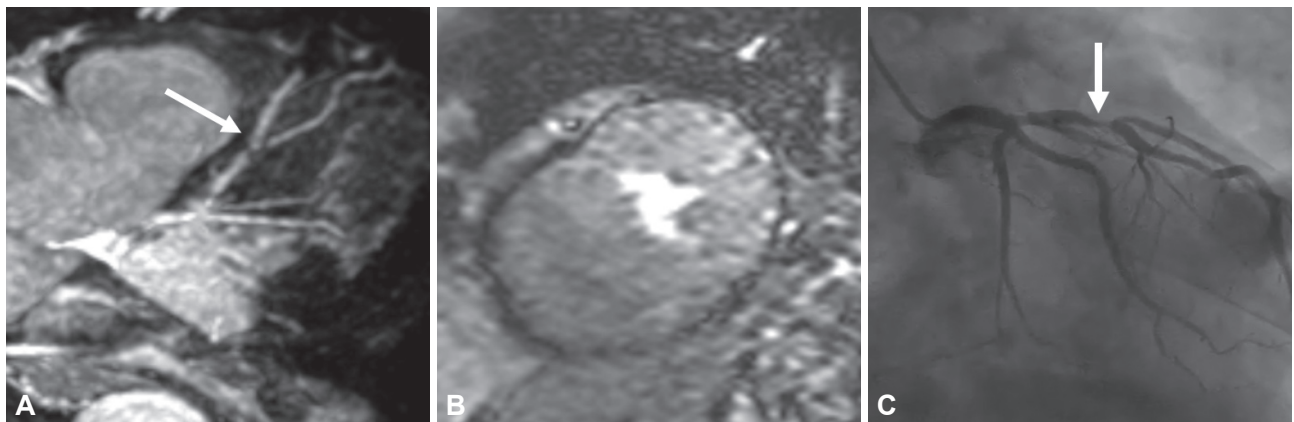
(A) Coronary MRA in a 67-year-old man with chest pain revealed significant LAD stenosis just proximal to the origin of the first diagonal artery (arrow). (B) Stress perfusion MRI, however, did not detect stress-induced ischemia. (C) On X-ray angiography, significant (75%) stenosis was detected (arrow). MRA: magnetic resonance angiography, LAD: left anterior descending.
